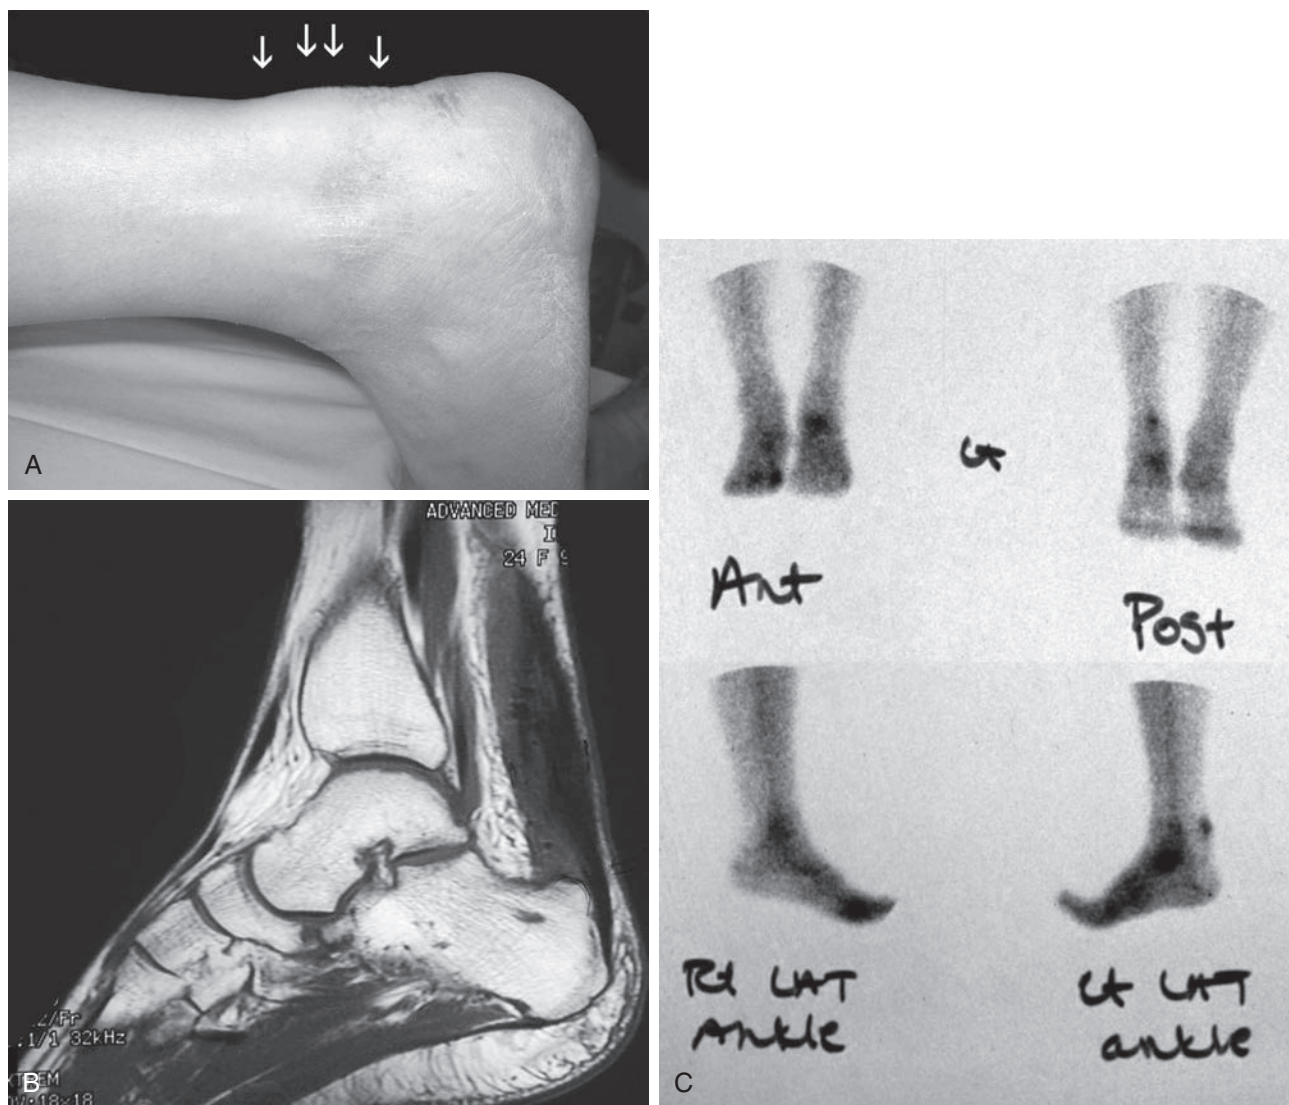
(A) Noninsertional Achilles tendinopathy with characteristic swelling 2 to 5 cm above dorsal aspect of calcaneus. (B) Magnetic resonance imaging shows thickened Achilles tendon. A Haglund's deformity also is noted. (C) Technetium bone scan demonstrating increased uptake in the Achilles tendon; the third phase of the scan, indicative of advanced intrasubstance degeneration.
